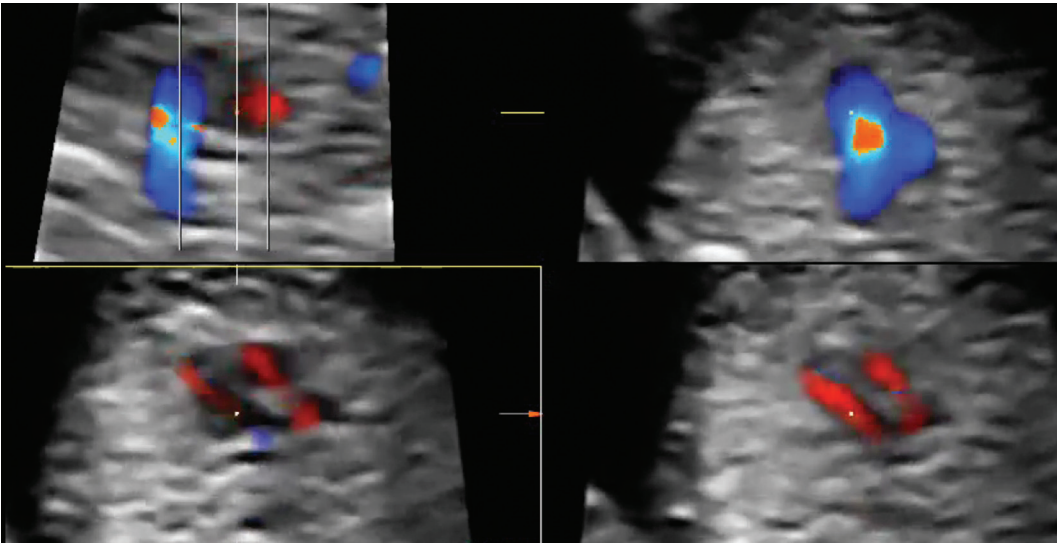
First trimester STIC ultrasound tomography of a normal heart
